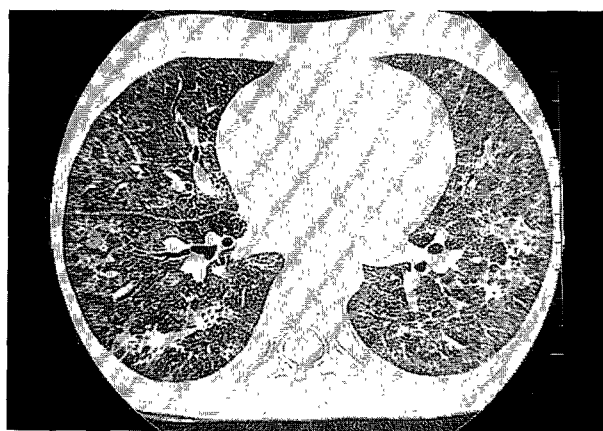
High resolutional CT scan of case 2 showing bilateral ground-glass opacity with interlobular septal thickening.
